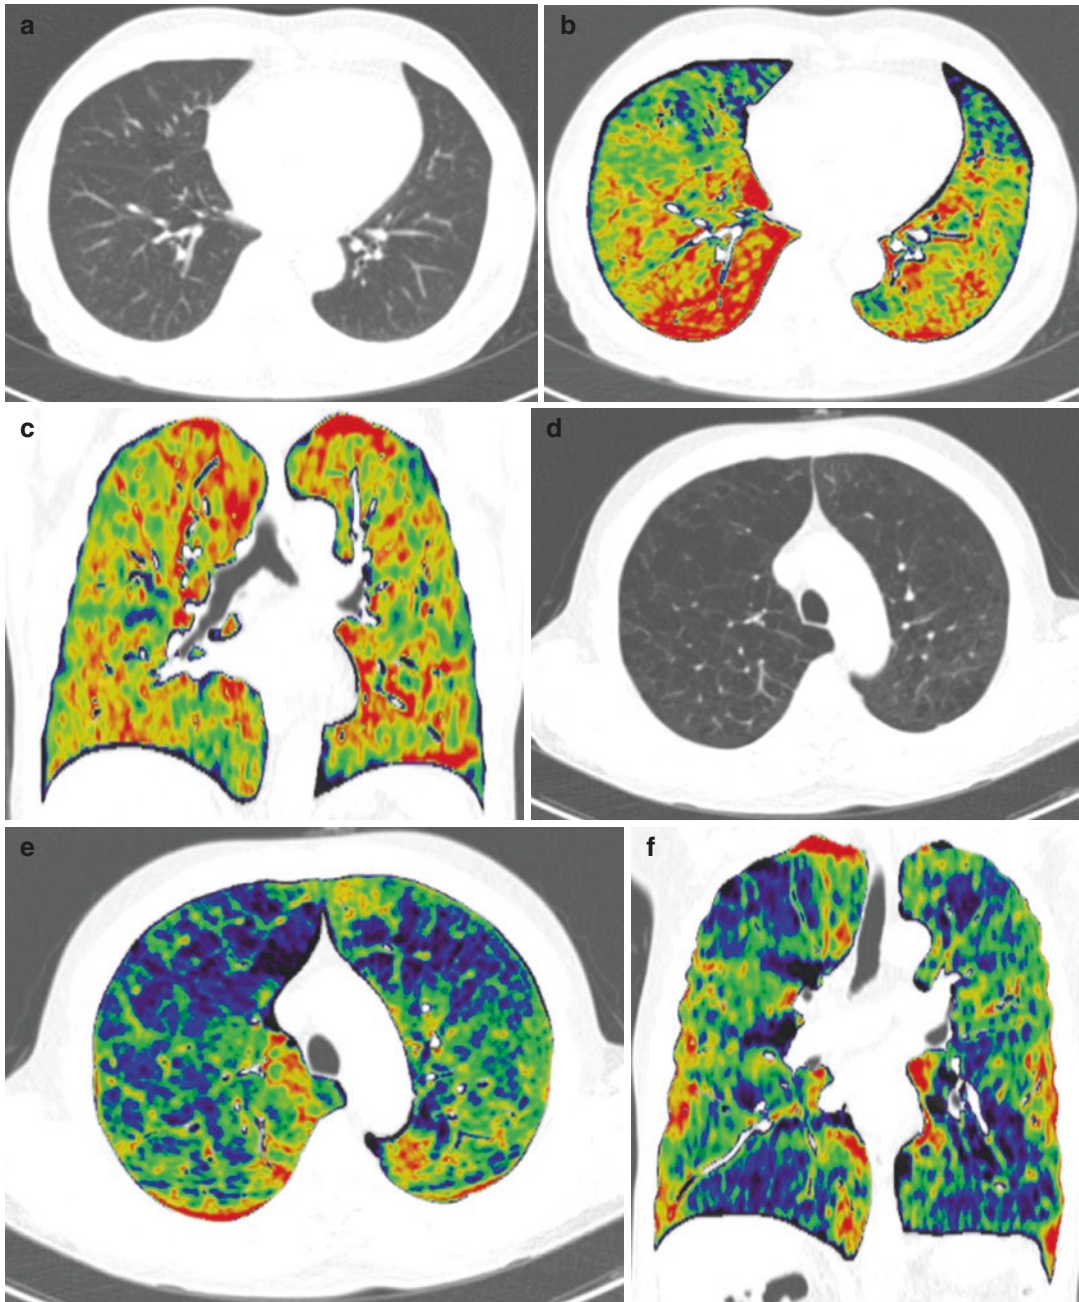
Iodine perfusion image with dual-energy CT in COPD patient. (a–c) Dual-energy CT in COPD patient with mild emphysema. (d–f) Dual-energy CT in COPD patient with severe emphysema. From iodine perfusion CT using dual-energy CT, (a, d) weighted conventional CT image and (b, c, e, f) iodine perfusion map are generated. Lung parenchymal destruction in COPD patient can
